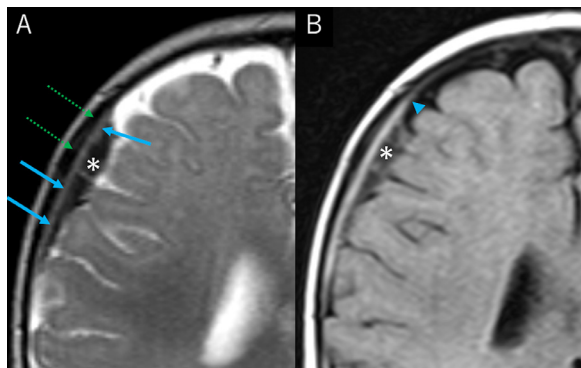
(A) Axial T2-weighted magnetic resonance imaging performed on post-hospitalization day 4, showing linear hyperintensity (arrows) between the inner table and hematoma (asterisk) with remarkable regression of the hematoma. (B) Fluid attenuated inversion recovery sequence performed at the same level, showing that the dura mater (arrowhead) is not displaced by the hematoma (asterisk). Dotted arrows in A: crack in the diploe.
